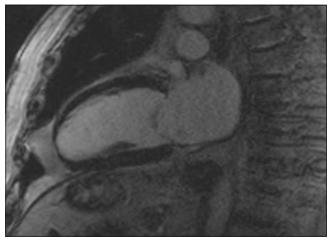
Cardiac Magnetic Resonance Imaging with gadolinium, demonstrating no areas of delayed contrast enhancement.
